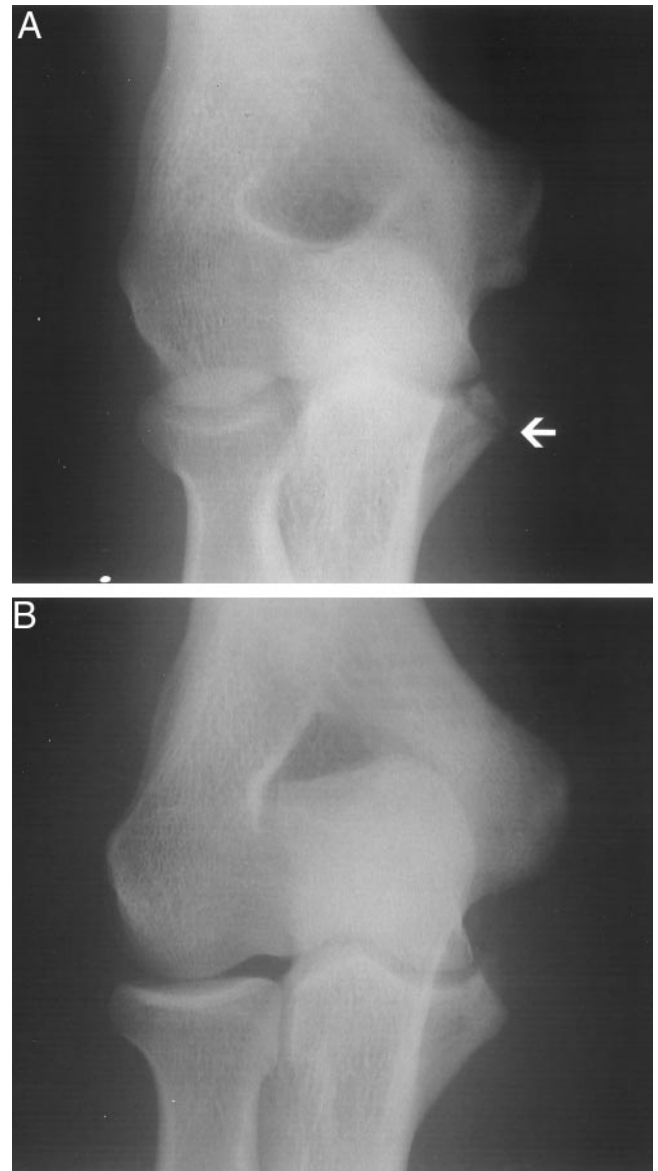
A, postoperative radiograph showing appearance of bony fragment and radiolucent bone anchors (arrow) (same patient as in Fig. 3). B, radiograph in the same patient with healed avulsion fracture.
